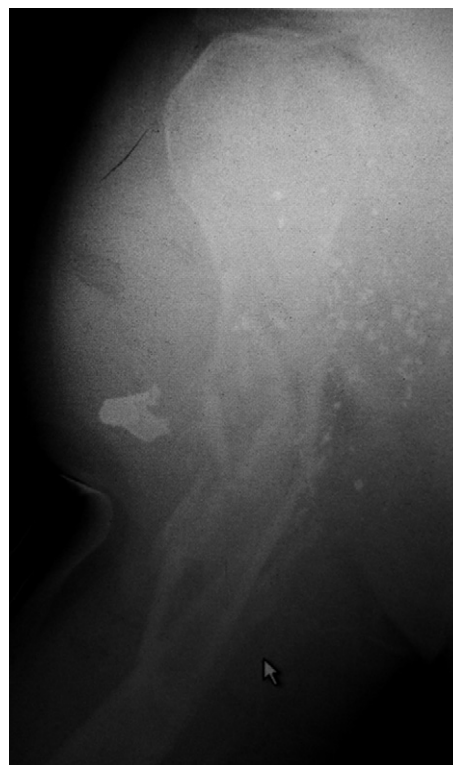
Radiograph of a high velocity gunshot wound to the right proximal humerus. The gunshot caused massive soft-tissue devitalization, along with a comminuted proximal humeral shaft fracture with substantial bone loss, and radial and axillary nerve palsies.
